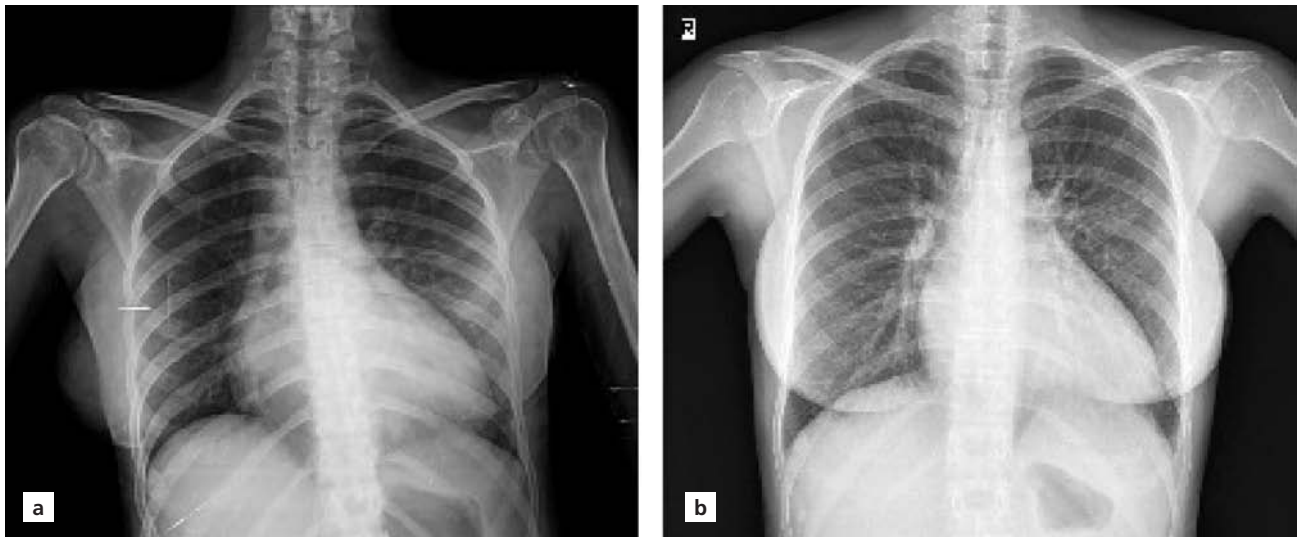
Chest radiography scan before the treatment.
